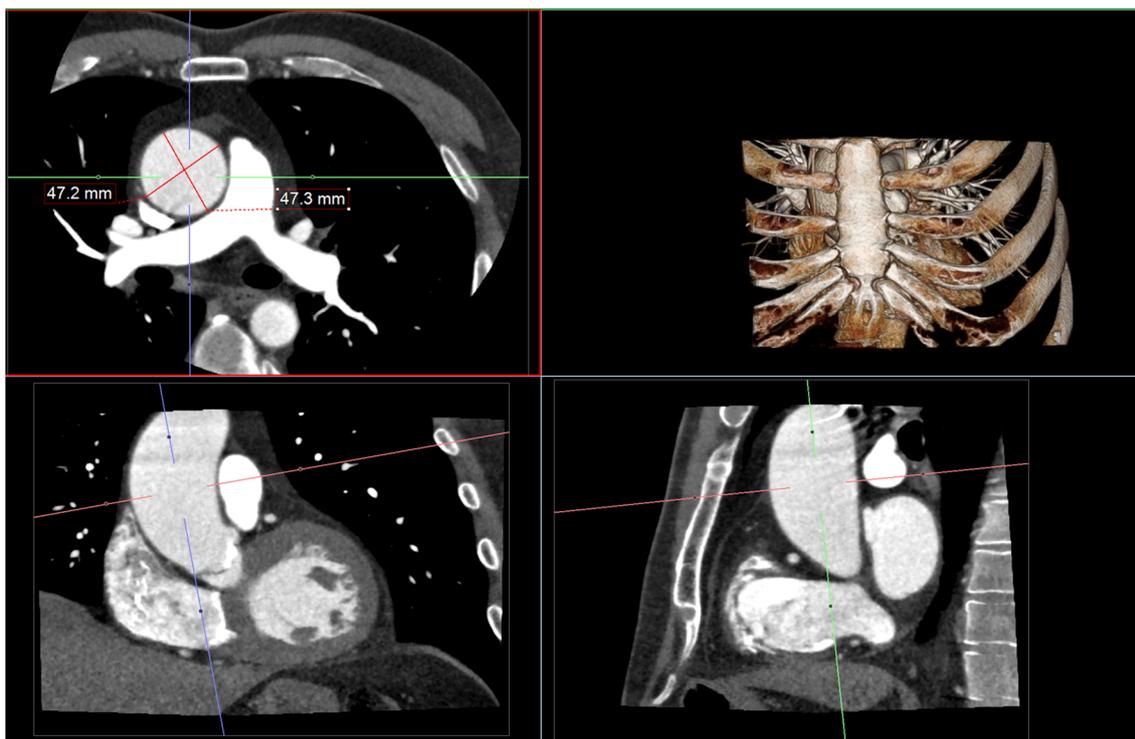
Multiplanar reformation of a cardiac CT. Measurements of the dilated tubular ascending aorta should be obtained perpendicular to the axis of blood flow
